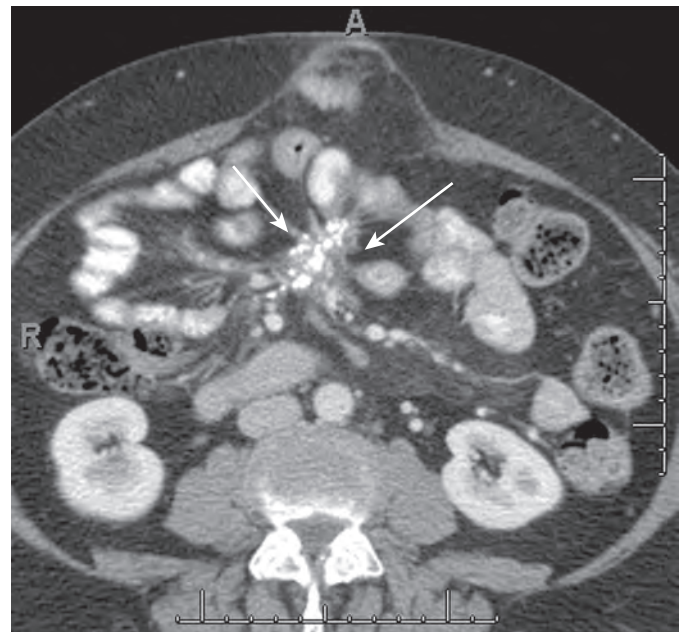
Sclerosing mesenteritis. Axial CT demonstrating sclerosing mesenteritis in another patient with mesenteric mass with multiple calcifications (arrows).
